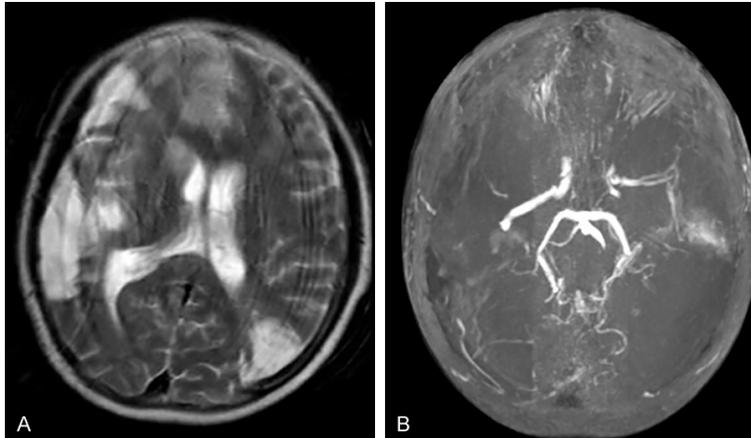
Brain MRI (A) demonstrated multiple hyperintense signals in the right frontotemporal region. The right temporal lobe swelled. DSA revealed no abnormal findings in right (B) and left (C) internal carotid arteries.
